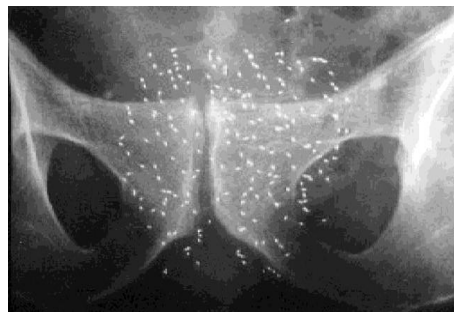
X-Ray of permanent seed implant brachytherapy
